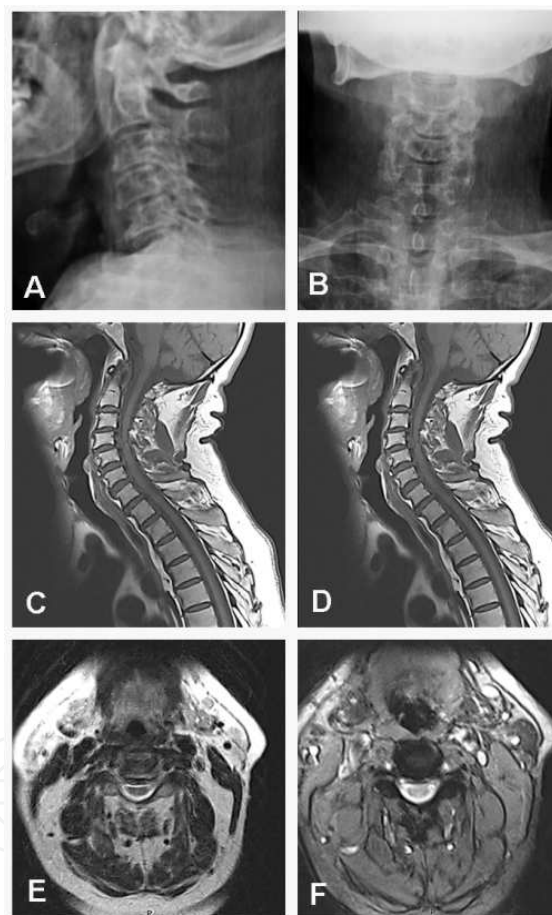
A. Lateral cervical spine radiograph with decreased general bone density; correction of the cervical lordosis; vertebral platforms sclerosis; decrease in intervertebral spaces at C3–C4, C4–C5, and C5–C6; syndesmophytes; reduction in diameter of intervertebral foramina at C2–C3, C3–C4, and C4–C5; decreased facet interface at C2–C3, C3–C4, and C4–C5; and spondylolisthesis at C4–C5. B. Anterior-posterior cervical spine radiograph with loss facet interface at C2–C3, C3–C4, and C4–C5; decreased vertebral space at C2–C3, C3–C4, and C4–C5. C. Sagittal MRI of cervical spine at stage T1 with vertebral platforms sclerosis, osteophyte formation, decreased height of IDs, and disc extrusion mainly in the intervertebral spaces at C4 and at C3–C4–C5. D. Sagittal MRI in T2 phase with decrease caliber medullary canal by the presence of posterior osteophytes, hypertrophy of posterior longitudinal ligament, and ID extrusion. E–F. MRI axial slices in T2 phase with reduced caliber of the cervical canal and compression of the spinal cord.
